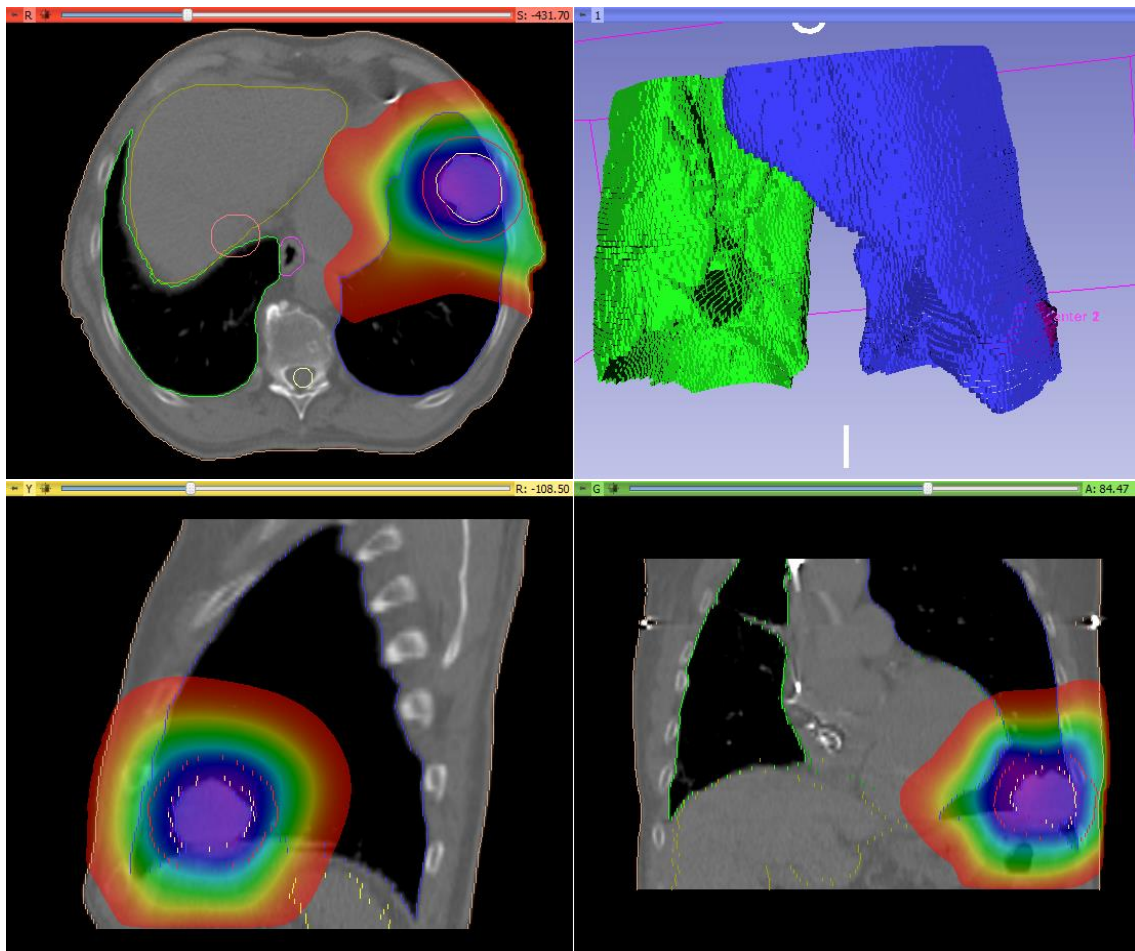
Example of a CT image from the thoracic district used for the RT dose planning.
